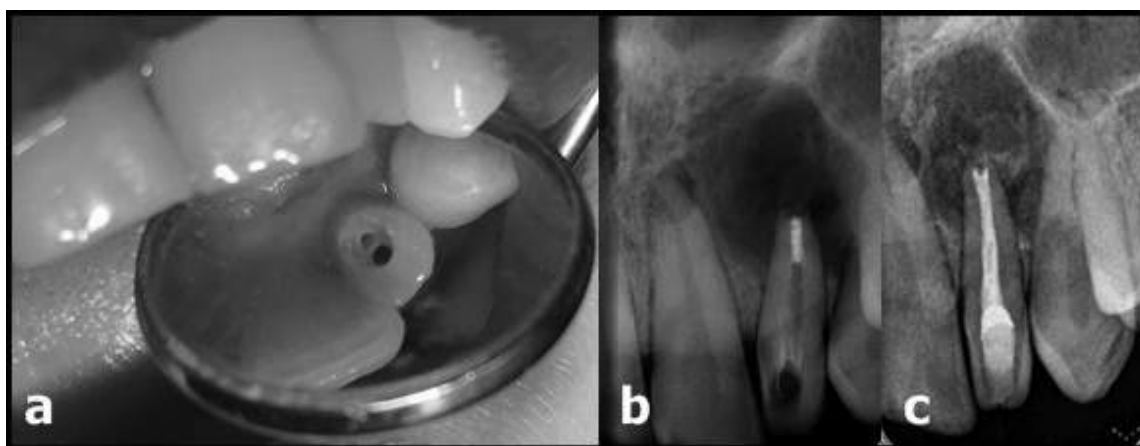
(a) Photograph of the access cavity shows that invagination and main canal, (b) radiograph shows that placement of MTA, (c) radiograph shows that root canal filling
